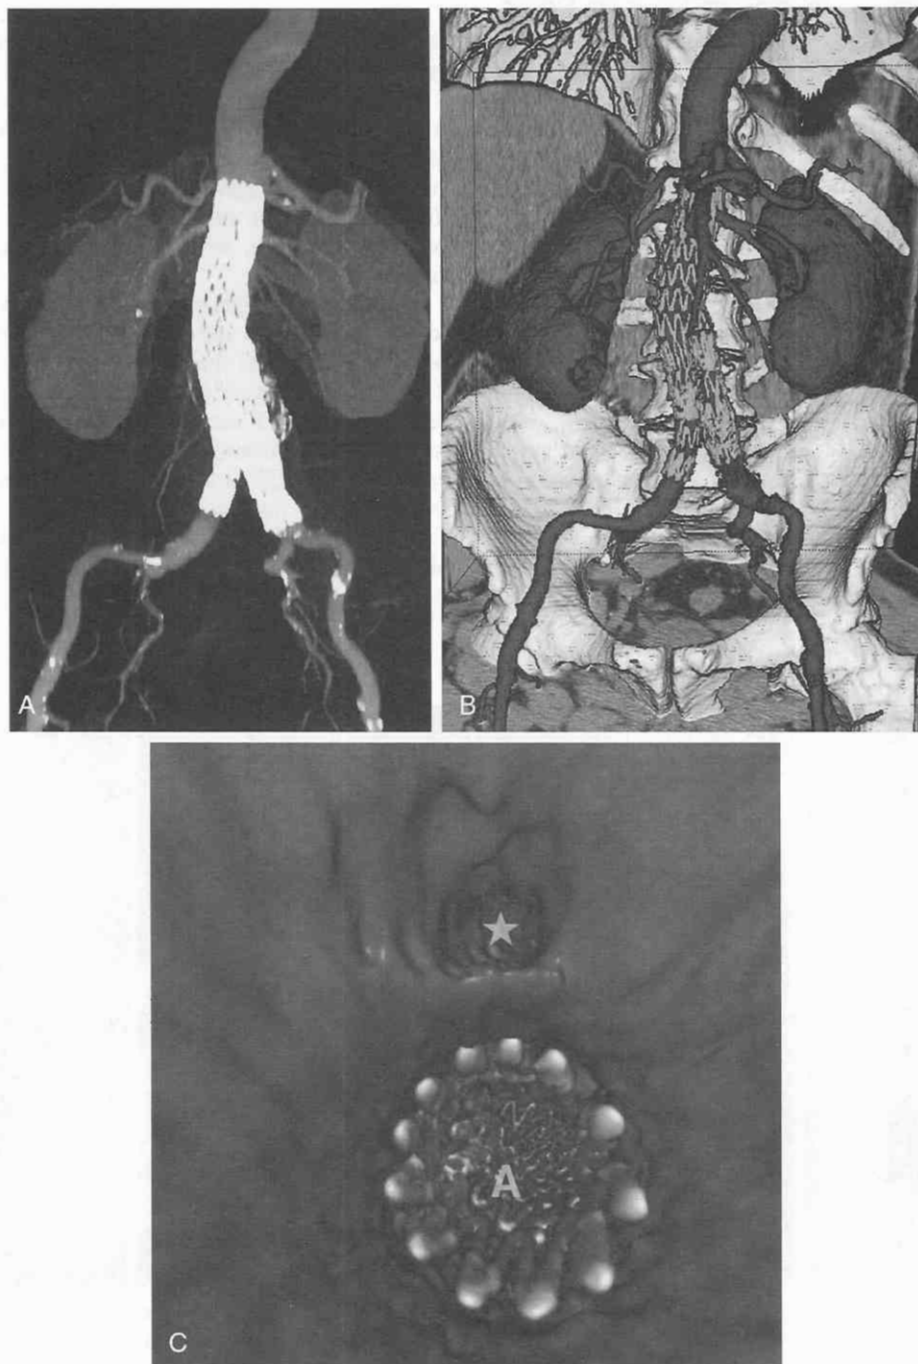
Aortic stent-graft in a 69-year-old man who underwent endoluminal repair of an abdominal aortic aneurysm. Postoperative multislice helical CT demonstrated graft patency and absence of an endoleak. Anteroposterior maximum-intensity projection (A), 3D surface-shaded display (B), and virtual arterioscopy (C) images show the wire frame of the stent-graft within the aorta. C, View from the superior portion of the abdominal aorta looking caudally into the celiac trunk (asterisk) and the main aortic lumen (A).
